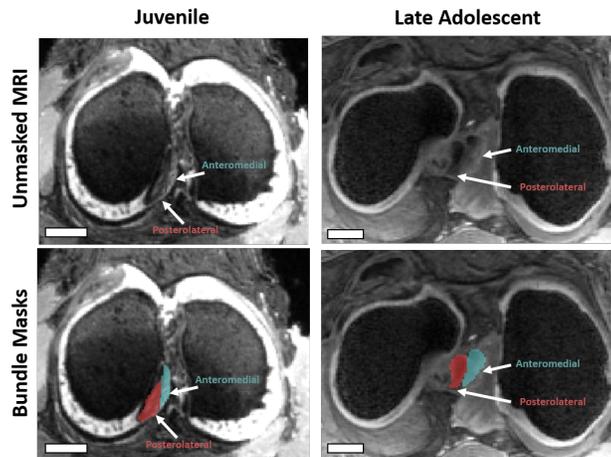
Figure A-3-2. Masking of the anteromedial and posterolateral bundles of the ACL via MRI. Sample images show for juvenile (3 months) and late adolescent (18 months) knee joints. Scale bars are 10 mm.
